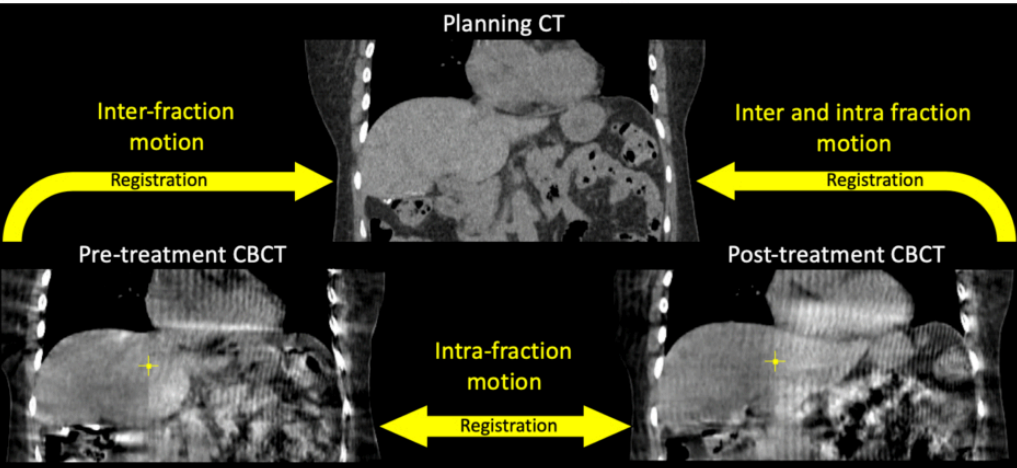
shows relations between planning CT, pre-treatment CBCT (during setup) and post-treatment CBCT that could be used to measure motion from inter-fraction, intra-fraction and both. Rigid registration was used to determine intra-fraction motion by computing iso-center point shifts (yellow crosshair) between pre/post CBCTs.
